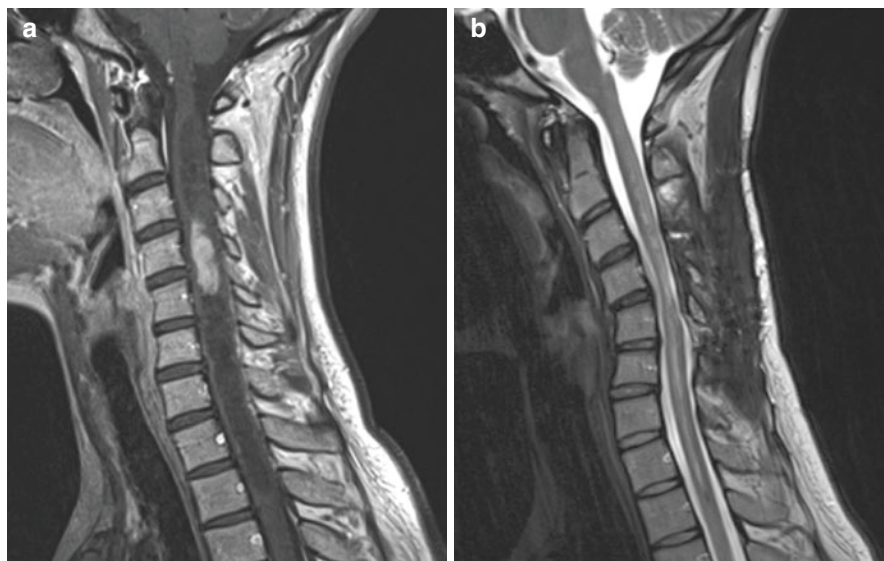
(a) This T1-weighted MRI with gadolinium demonstrates an ependymoma at C4–C5 with associated syringomyelia above and below the tumor in a 26-year-old woman. The tumor shows bright contrast enhancement and is well demarcated from the surrounding cord tissue. (b) The postoperative scan shows the complete collapse of the syrinx after tumor removal. Despite reinsertion of the laminae, a kyphotic deformity developed
